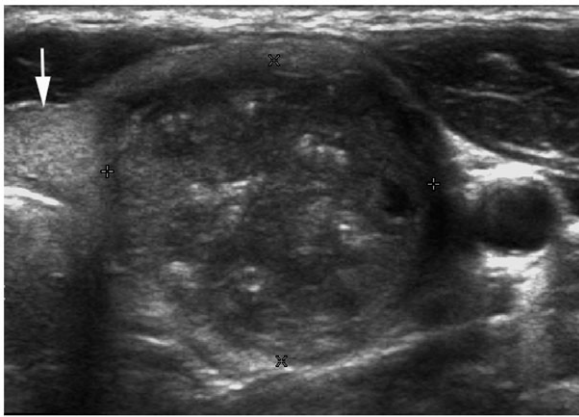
Transverse ultrasound image of the left lobe of the thyroid and isthmus (short arrow). The left lobe of the thyroid contains a heterogeneous echogenic nodule, with multiple small foci of calcification (between callipers). Fine-needle aspiration revealed papillary thyroid carcinoma.
